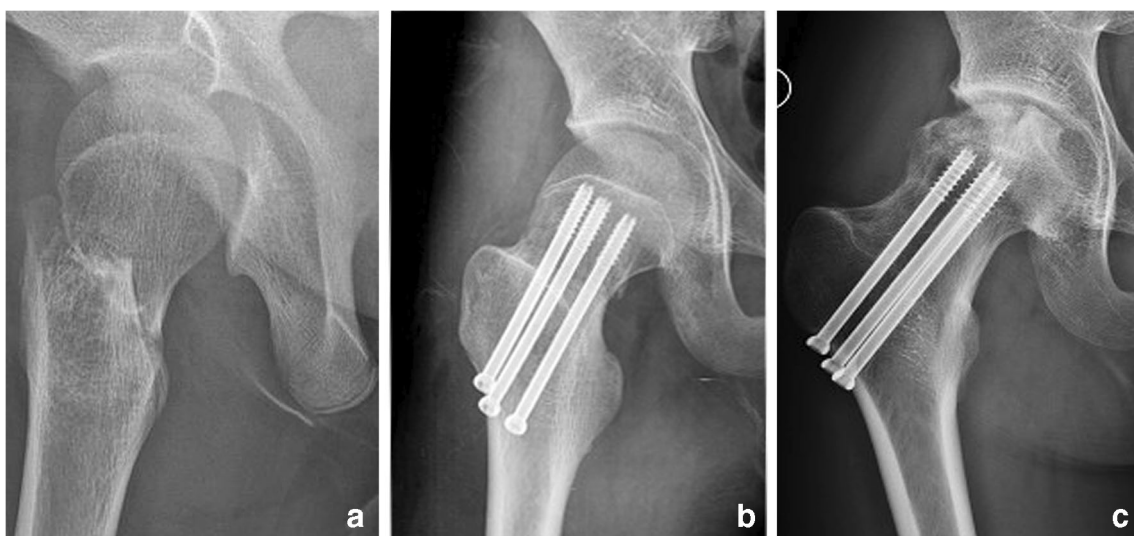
Radiographs of a 12-year-old boy with a displaced femoral neck fracture. a Lateral (L) view of a Delbet-Colonna type-II fracture, with the amount of initial translation (T_L) over 29%. b AP view after closed
